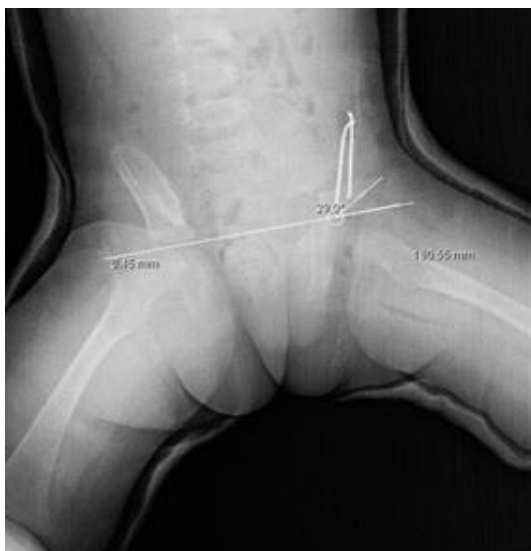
Measurement of the acetabular index on early postoperative pelvis anterior-posterior (AP) radiography
